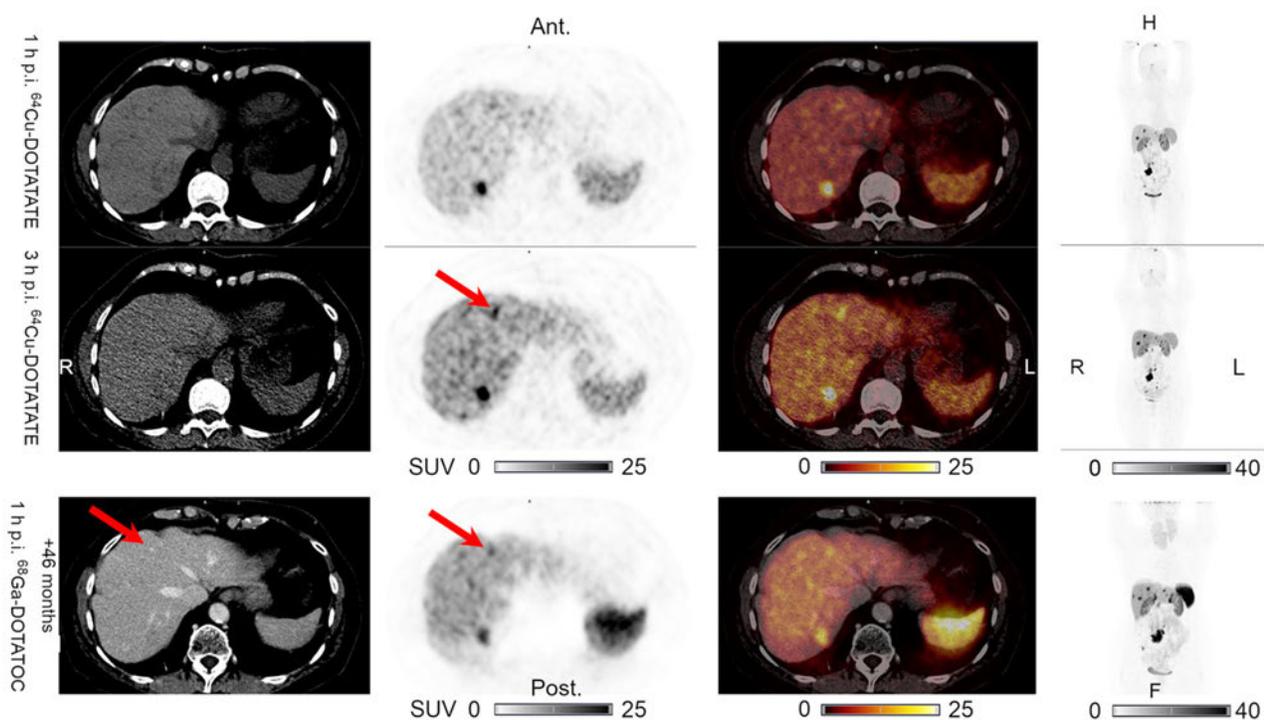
Patient 5: One additional liver lesion visible on 3h p.i. ^{64}Cu -DOTATATE PET (middle) but not on 1h p.i. ^{64}Cu -DOTATATE PET (top). No visible CT correlate. Discordant liver lesion visible on later 1h ^{68}Ga -DOTATOC-PET/CT (39 months after the scan) without visible CT correlate (bottom). True positive. From left to right: CT, PET, fused PET/CT and MIP with corresponding SUV color bars below. Ant: anterior, Post: posterior, R: right, L: left, H: head, F: feet.
